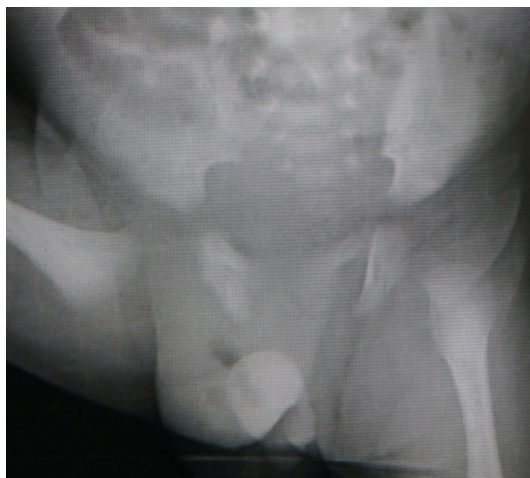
Abdominal X-ray demonstrated gas in the right hemiscrotum.
